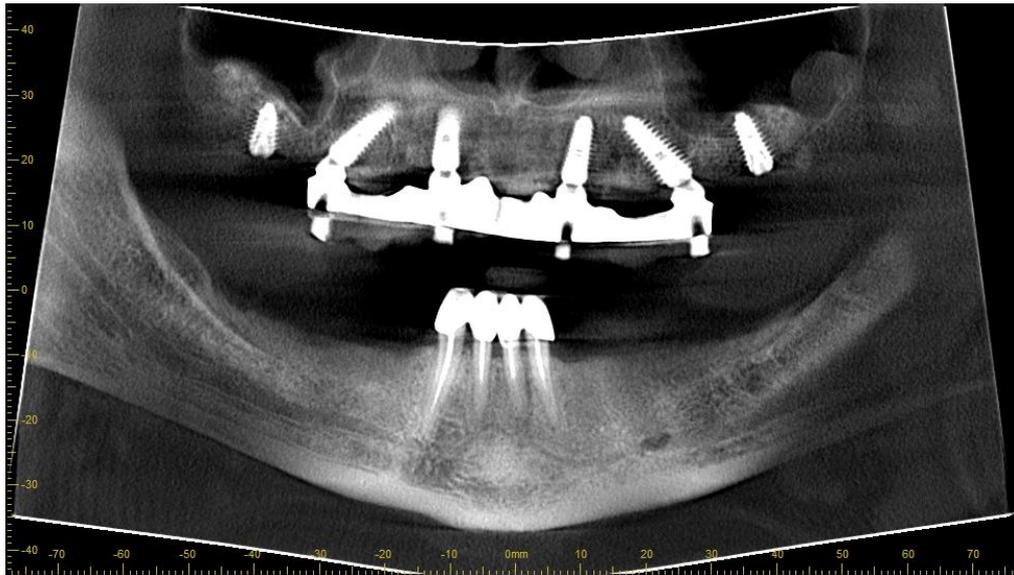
Orthopantomogram after delivery of the orthopedic structure on artificial supports.
